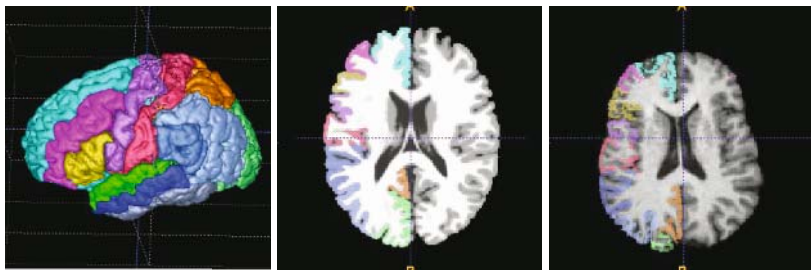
Atlas-based brain image segmentation. (Left) A surface rendering of the labeled atlas used in this work. (Middle) The grey-matter labels for one hemisphere are shown superimposed on the underlying structural image of the atlas. (Right) The atlas is registered to the T1-weighted image of one subject, and the warped grey-matter labels for one hemisphere are shown superimposed on the subject’s structural image. The partition results of the subject’s corpus callosum is shown in figure 2, which also contains the color-coded list of the cortical regions delineated in the atlas, further details of which can be found in [12].
